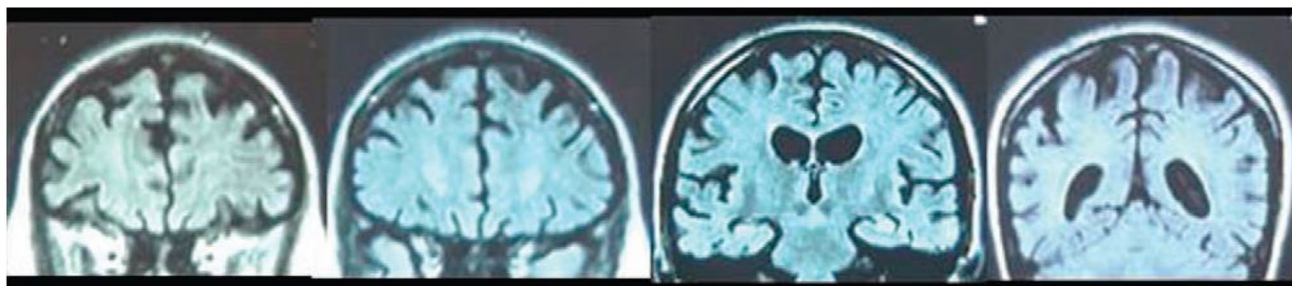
Coronal MRI slices (anterior to posterior) from a 35 years old female patient carrying L424V *PSEN-1* mutation. From A. Robles et al. (2009). American Journal of Alzheimer's disease and other dementias, 24(1); p.41 copyright © 2019. Reprinted by Permission of SAGE Publications, Inc.
